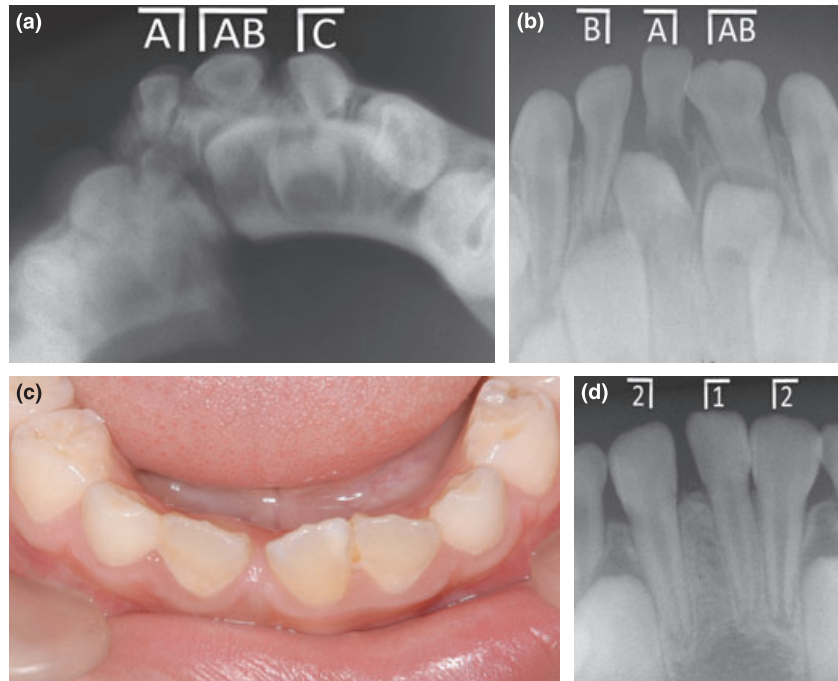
Case 3. (a) X-ray finding at the first visit (2 years and 6-months old). A dislocated fracture was observed in the symphyseal region of the mandible. (b) X-ray finding (3 years and 3-months old). The root of the right deciduous central incisor was remarkably absorbed. The unerupted right central incisor showed abnormal formation of the crown and root. (c) Intraoral finding (7 years and 6-months old). The right central incisor was lost. The crown of the left central incisor had formed almost normally. (d) X-ray finding (7 years and 6-months old). The root of the left central incisor was developing normally.
